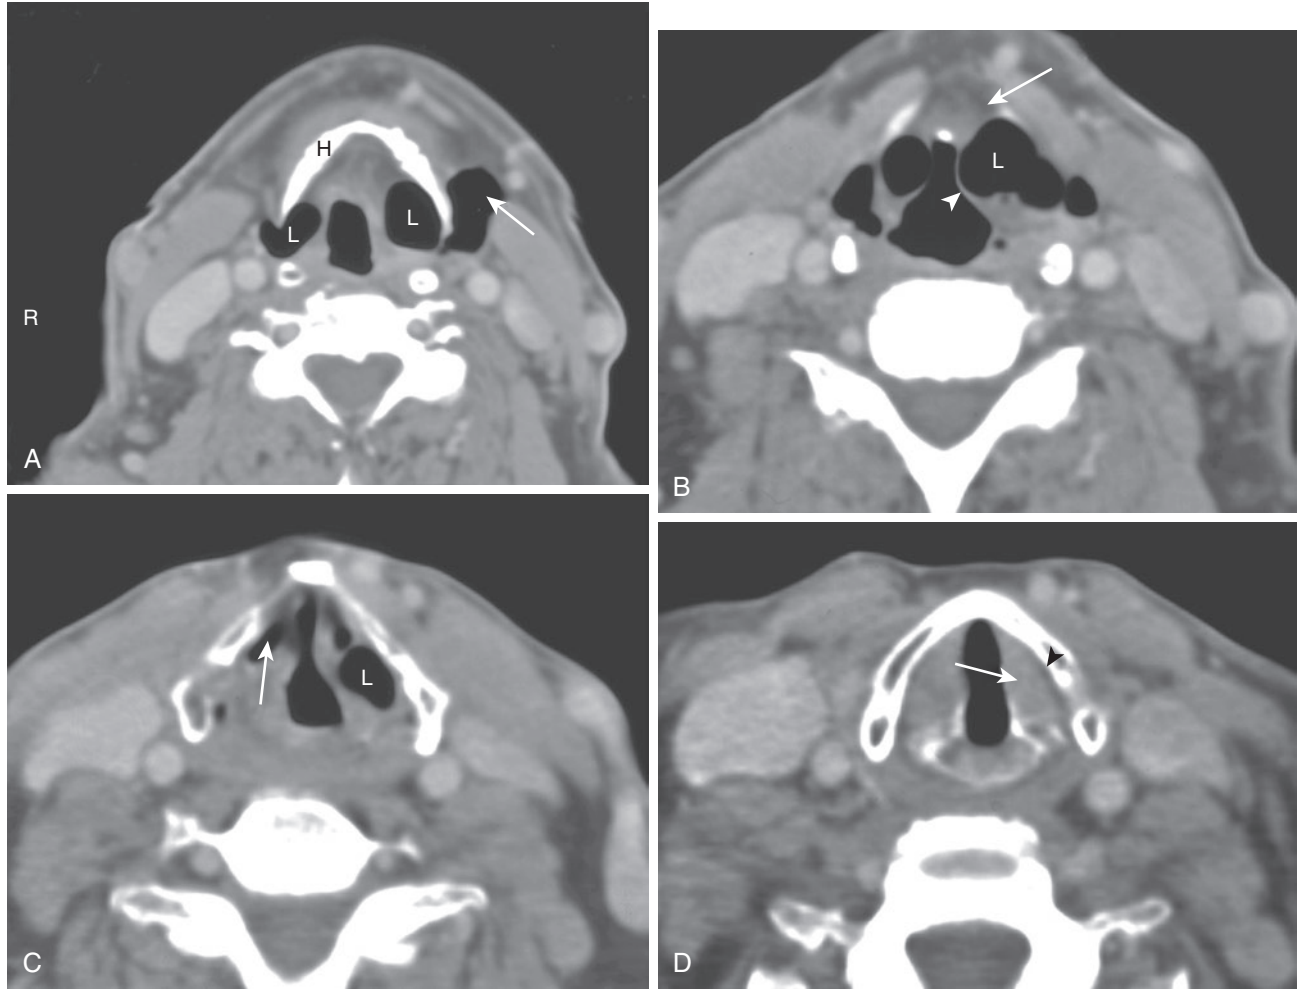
Bilateral air-filled laryngoceles (axial CT).
